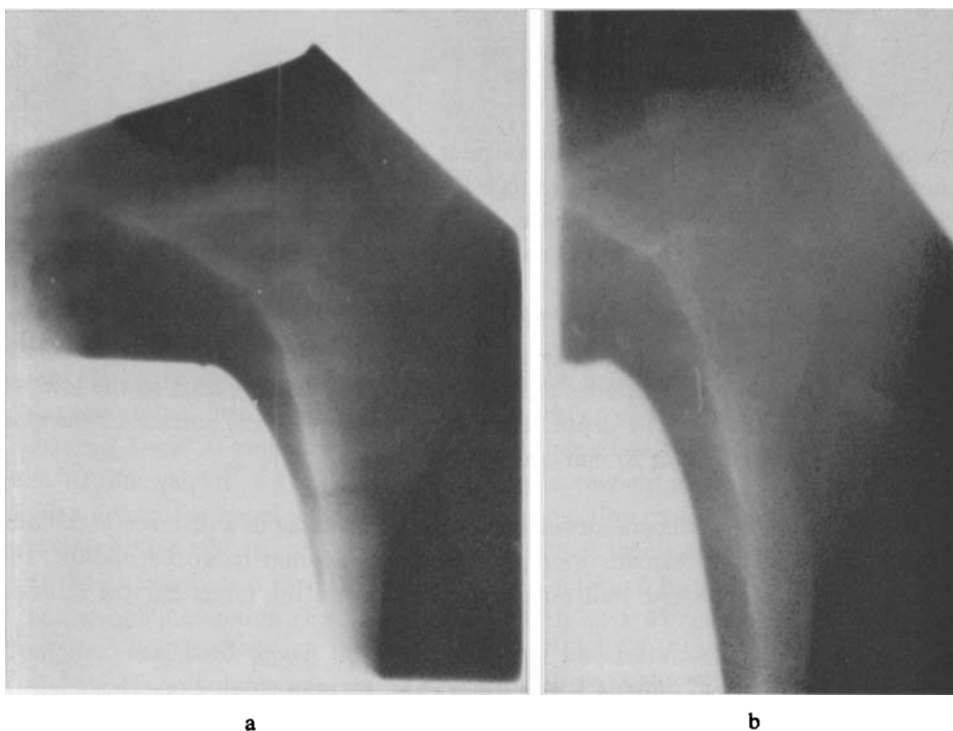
Films during irradiation (6 MV roentgen rays, Linac, SSD 100 cm) of a) ventral and b) dorsal beam towards axilla and supra- and infraclavicular fossae (cf. Fig. 5 a, b).
